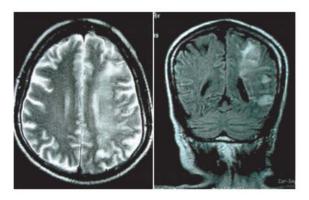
Repeat MRI scan showing major left MCA infarct.
